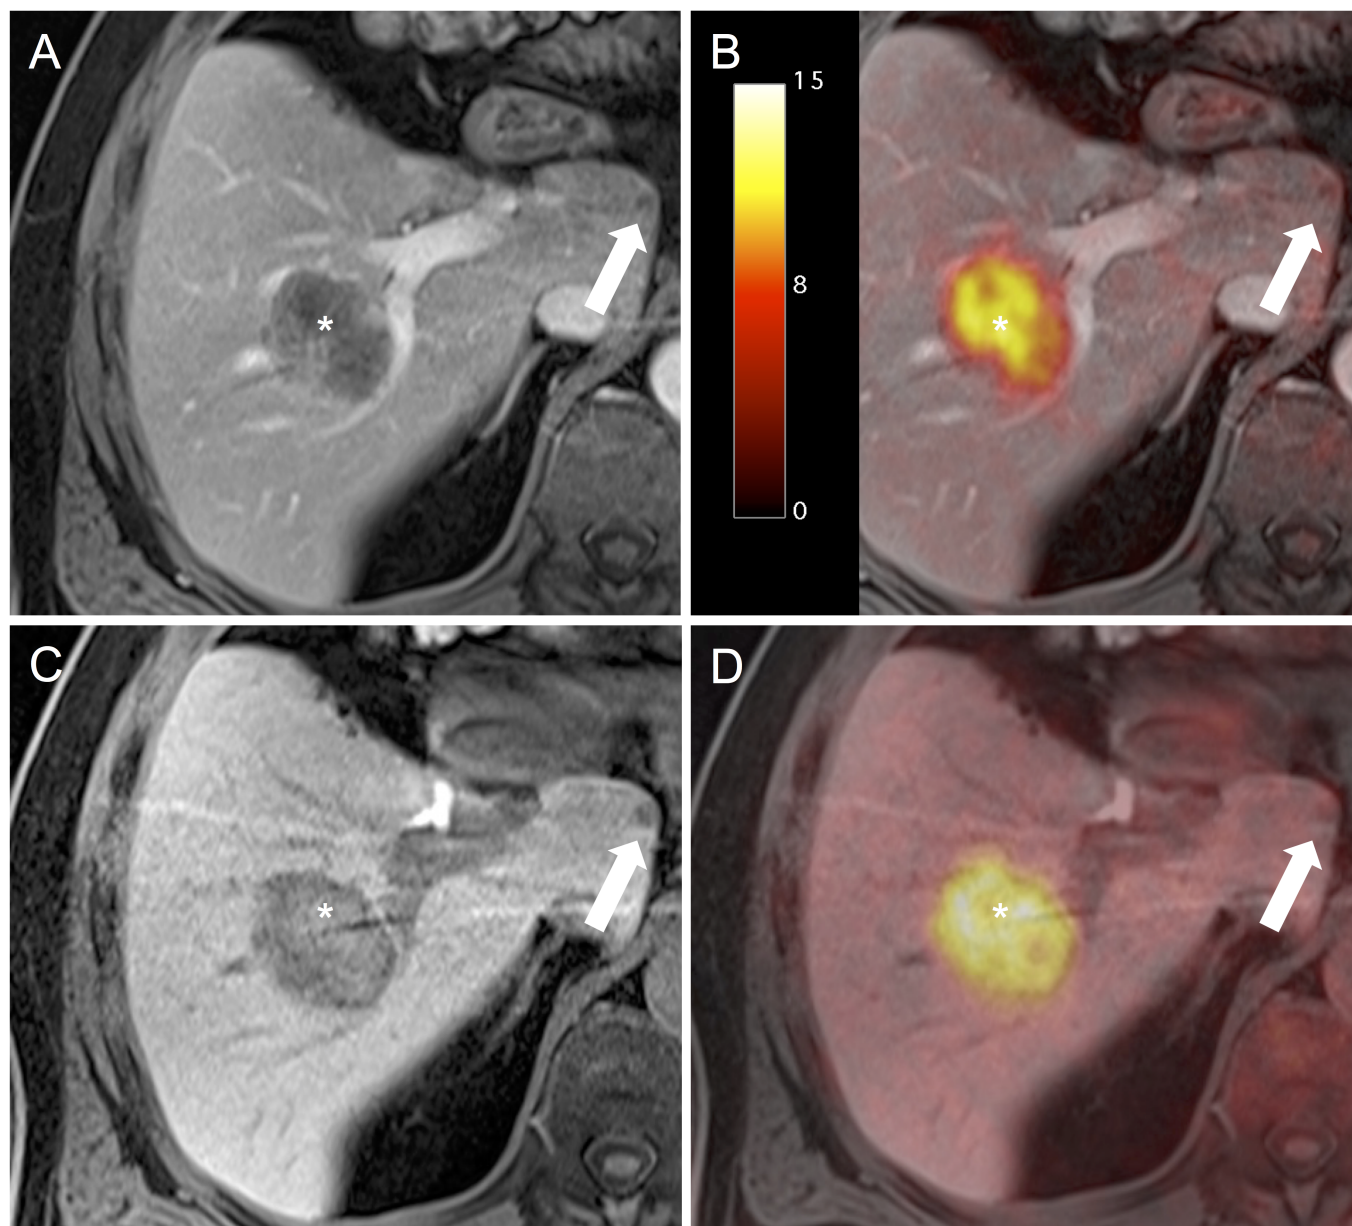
A 61-year-old male patient with liver metastases from a Colorectal Carcinoma. The large metastasis with intense ^{18}F -FDG-uptake in the right central liver lobe is clearly visible in all datasets (*). The metastasis in the Lobus caudatus does not show increased ^{18}F -FDG-uptake (A, D) and is hardly detectable in the arterial-phase (B) but is clearly detectable as hypointense lesion in the liver-specific phase (C).
